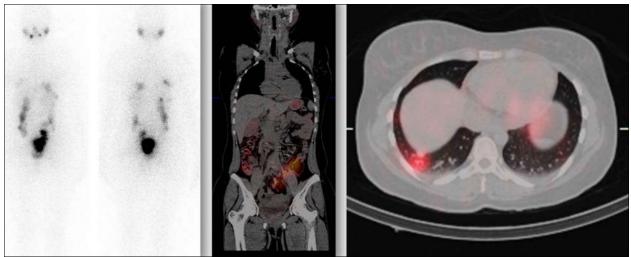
Post second radioiodine ablation therapy (200 mCi) whole body planar, fusion SPECT-CT coronal whole body and axial chest views show I-131 avid 8mm solitary pulmonary nodule in the basal segment of right lung. Physiological tracer distribution to the salivary glands, gastrointestinal tract and urinary bladder is seen.
